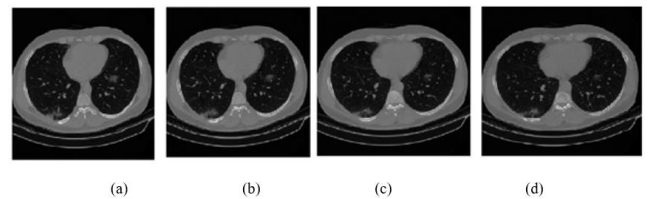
SPIHT reconstructed output corresponding to the COVID 19 CT data set (ID5 – ID8)
